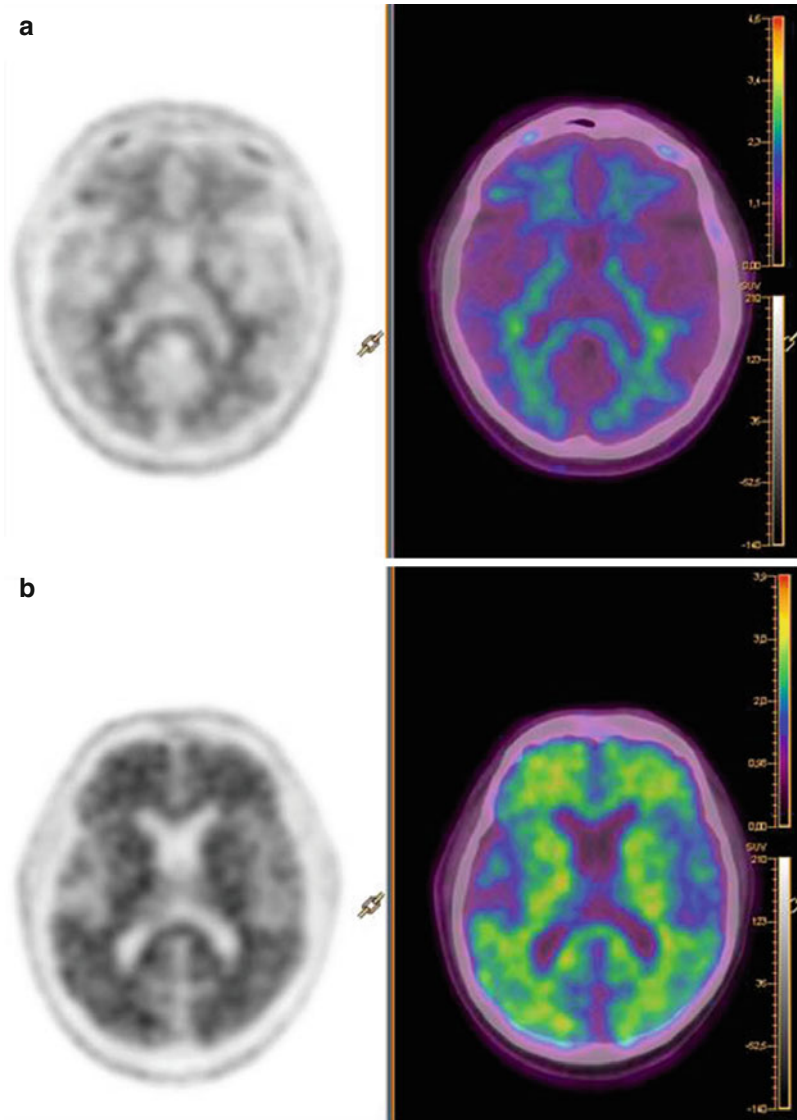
Images of ^{18}F -florbetapir PET (*left*) and PET-CT (*right*) in DS patient without cortical amyloid burden (a) and in DS patient with high cortical amyloid burden.
